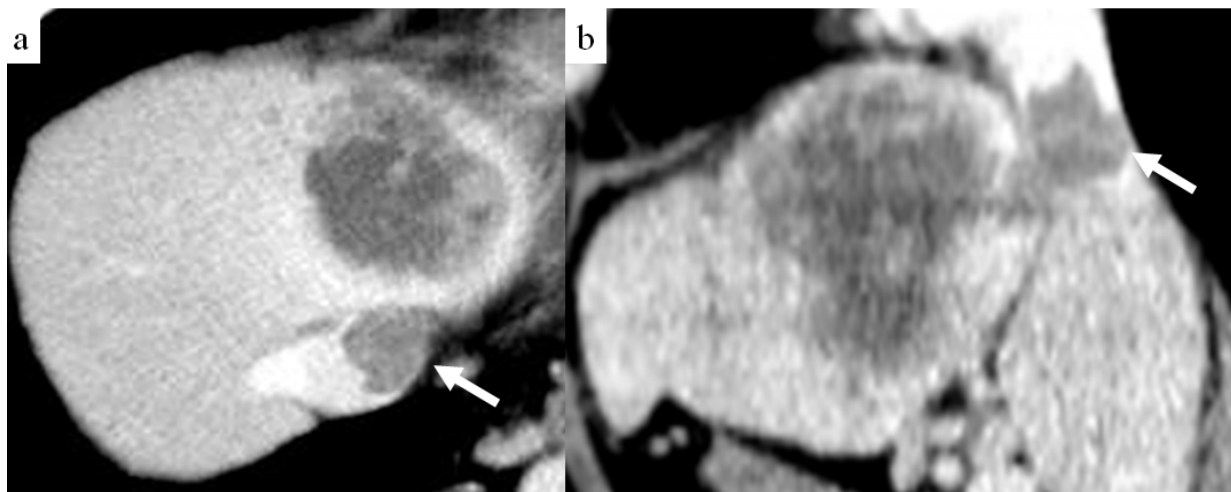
Computed tomography image of hepatocellular carcinoma. The arrow indicates the tumor thrombus extending to the intra-pericardial inferior vena cava. (a) transverse sections, (b) sagittal section.
